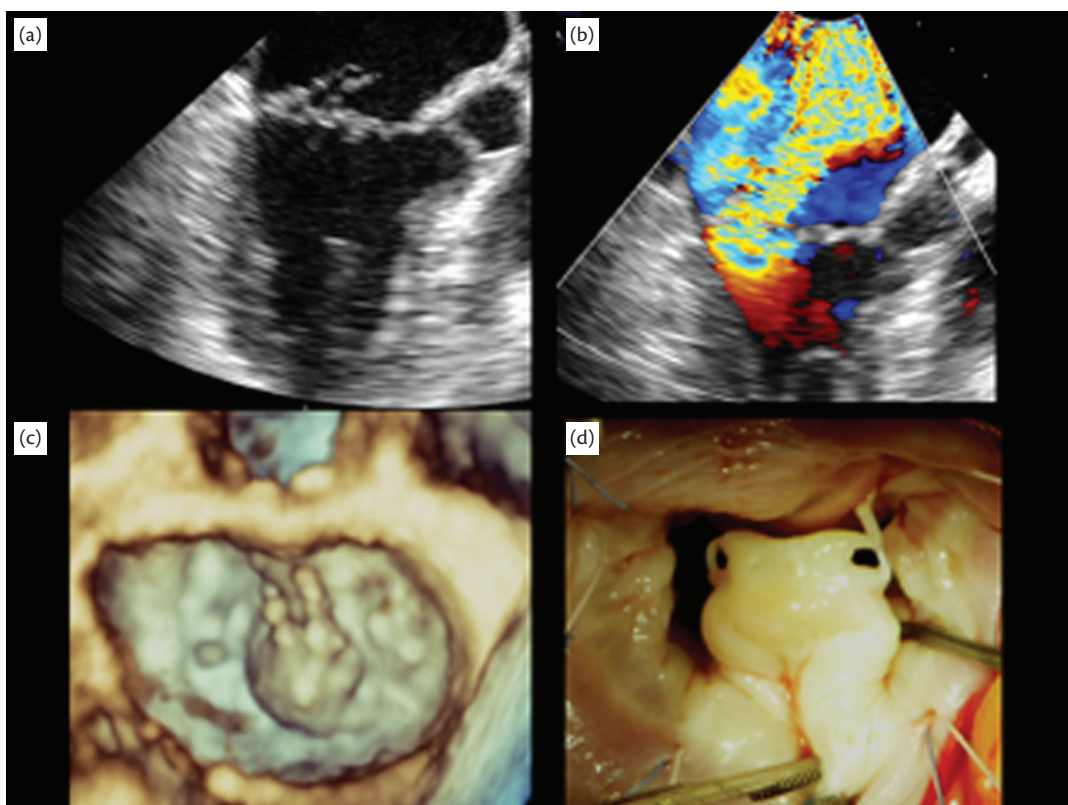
Mitral valve with fibroelastic deficiency. Prolapse and flail due to ruptured chordae tendineae with related severe mitral regurgitation. (a) Two-dimensional TOE. (b) Colour Doppler TOE. (c) Real-time three-dimensional TOE. (d) Intraoperative finding.
